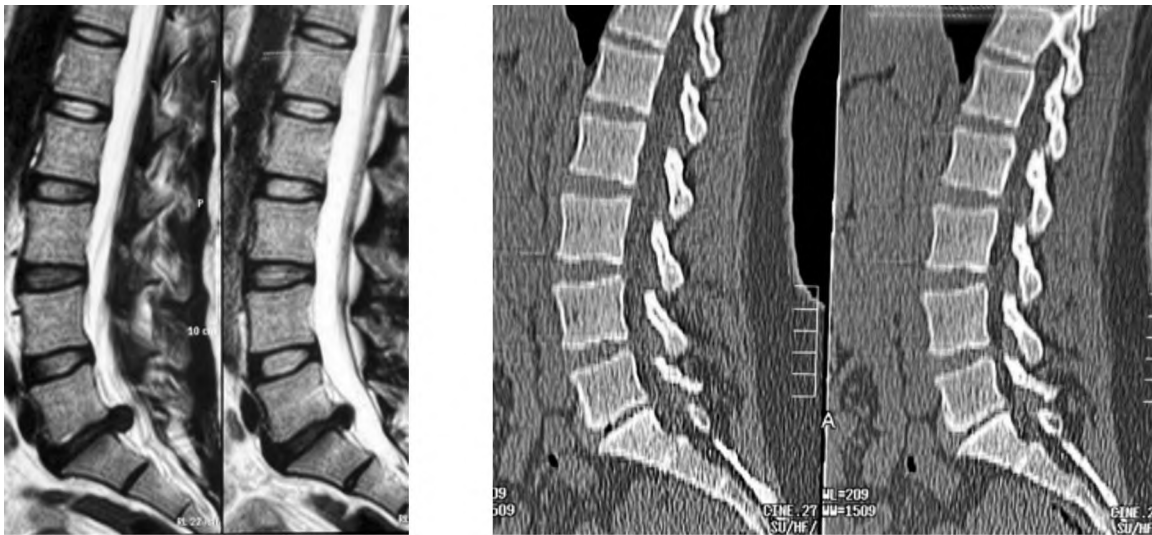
Ct & MRI LSS Sagittal cuts showing L-5S1 disc prolapse with collapsed disc space at index level "preoperative".
